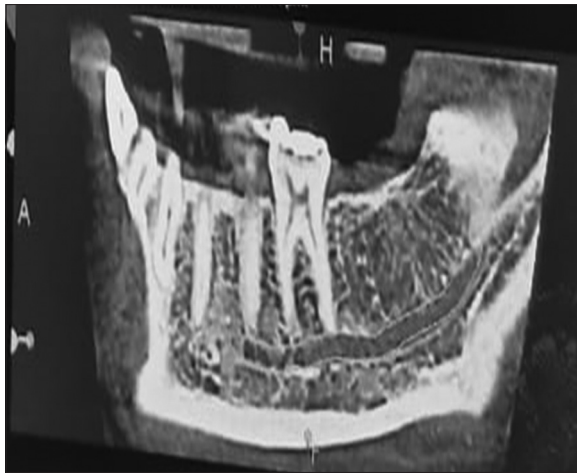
CBCT sagittal view at post-operative 2nd year
